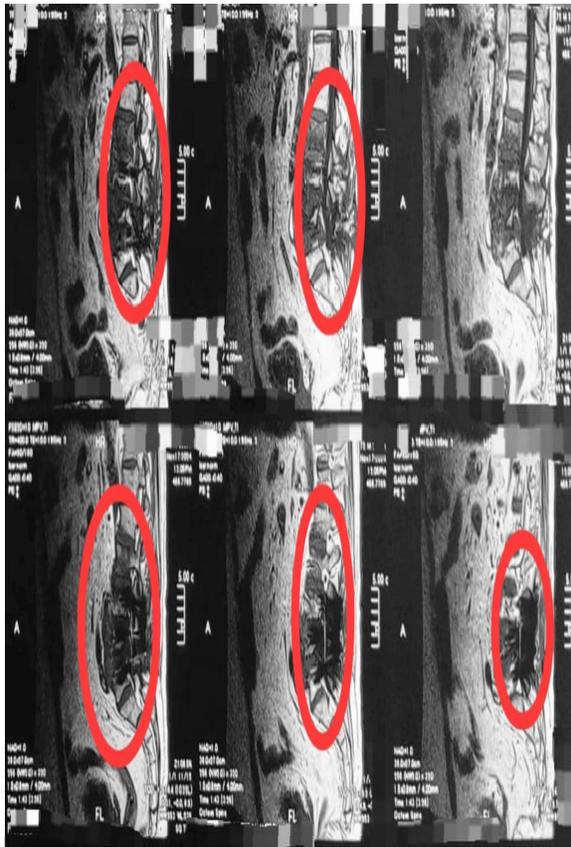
MRI Lumbosacral Spine: Stenosis
